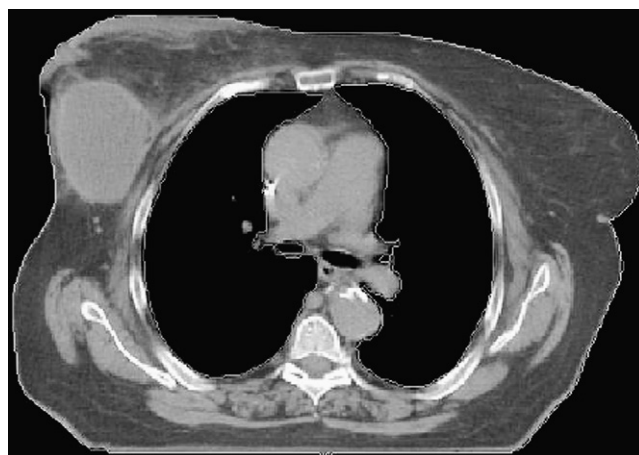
Treatment-planning CT in the supine position (arms elevated), showing postoperative seroma in the right breast.
